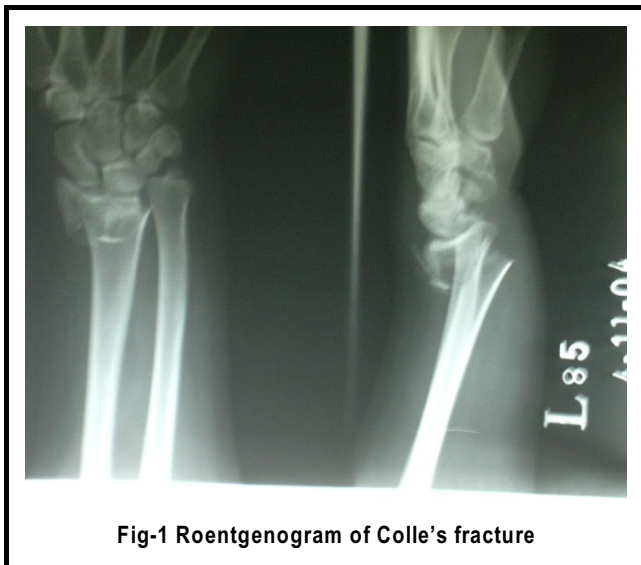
Roentgenogram of Colle's fracture
